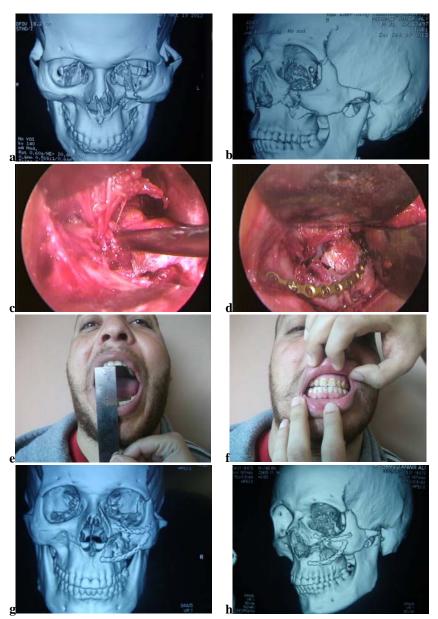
(a & b) 35 years old male patient with Lt zygomatico-maxillary, Lt zygomatic arch, Lt infraorbital rim and Lt orbital floor fractures. Preoperative 3D CTof the patient show Lt zygomatico-maxillary, Lt zygomatic arch, Lt infraorbital rim and Lt orbital floor fractures. (c & d) Intraoperative endoscopic pictures showing, infraorbital rim fracture and infraorbital nerve appear, patients underwent reconstruction of maxillary wall with bone graft and plates. (e & f) 6 Months post operative 3D CT reconstruction.
